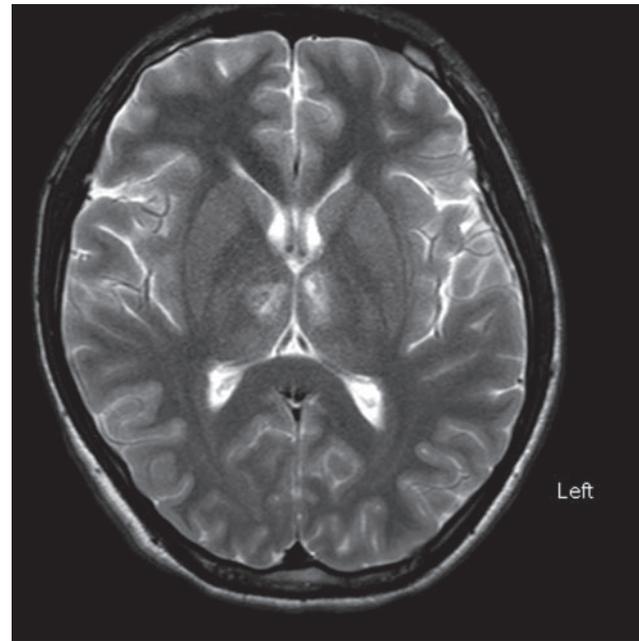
T2 weighted image of MRI brain on admission reveals symmetrical high signal intensity over bilateral medial thalami.
